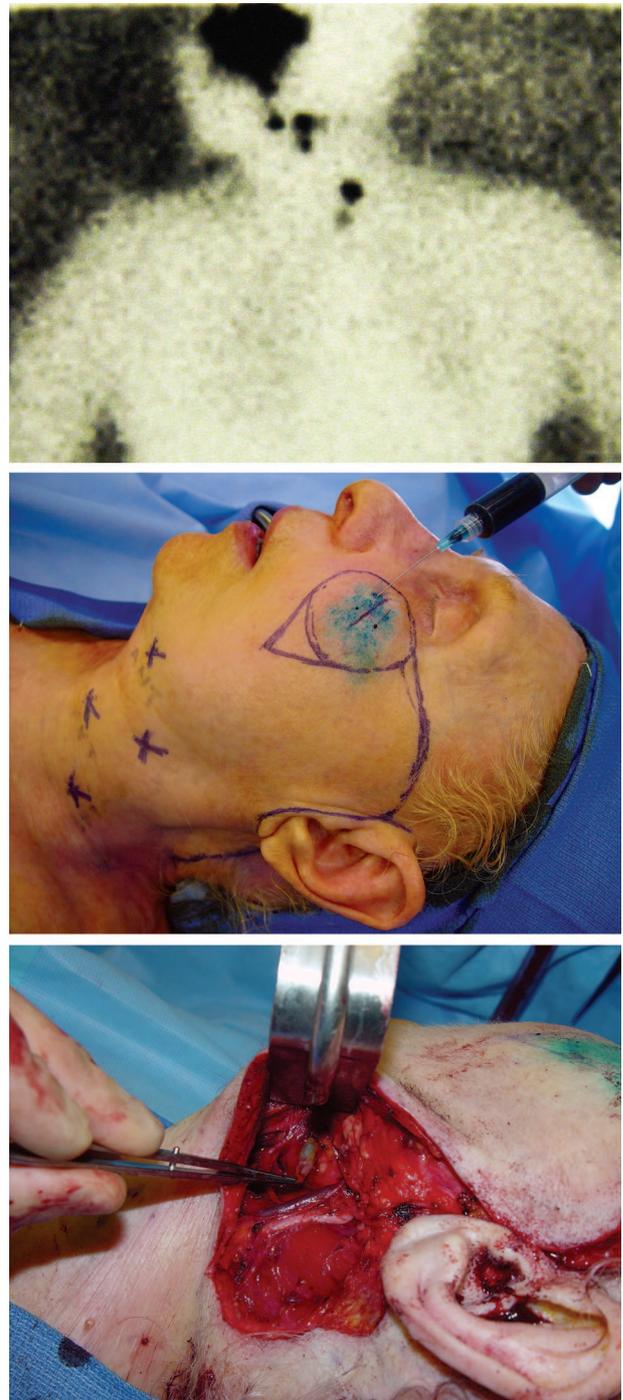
(Above) Lymphoscintigraphy demonstrates drainage to multiple nodal basins including levels IV and V. (Center) The patient is marked for excision of melanoma following sentinel node biopsy. Isosulfan blue is injected at the melanoma site and the markings extend inferiorly to allow for exposure of level IV and V nodal basins. (Below) The extension of the face lift incision down the posterior hairline allows for adequate surgical access to nodal basins at levels IV and V. This incision is easily incorporated into a cervicofacial flap used for closure of the primary melanoma site.
